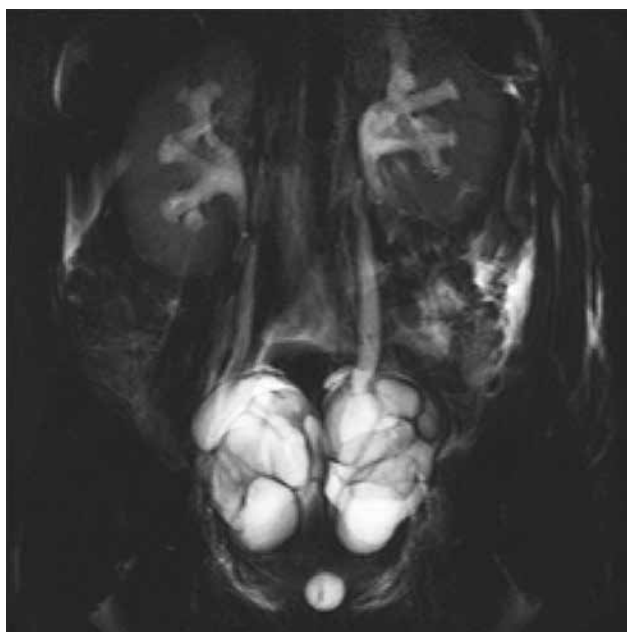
Ultrasound showing bilateral stimulated enlarged ovaries compressing both ureters resulting in bilateral hydronephrosis.
